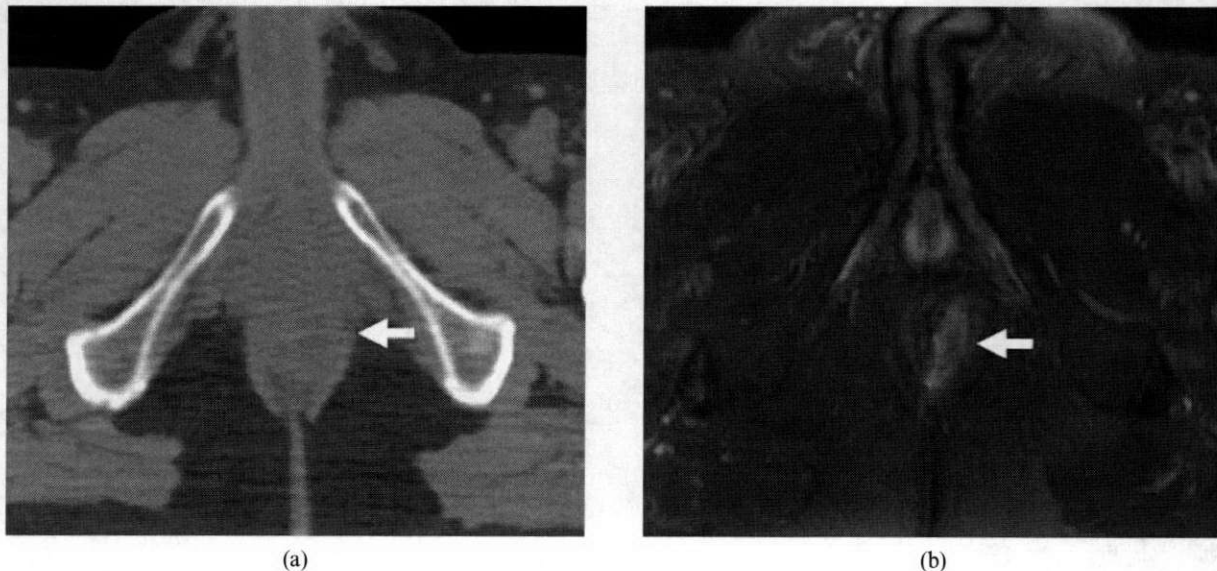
Co-registered (a) CT and (b) MRI scans showing a rectal cancer in the lower rectum extending to the anorectal junction with invasion of the left posterolateral wall. This is easily seen on the T_2 weighted MRI scan as a hyperintense signal region that is not visible on CT.
